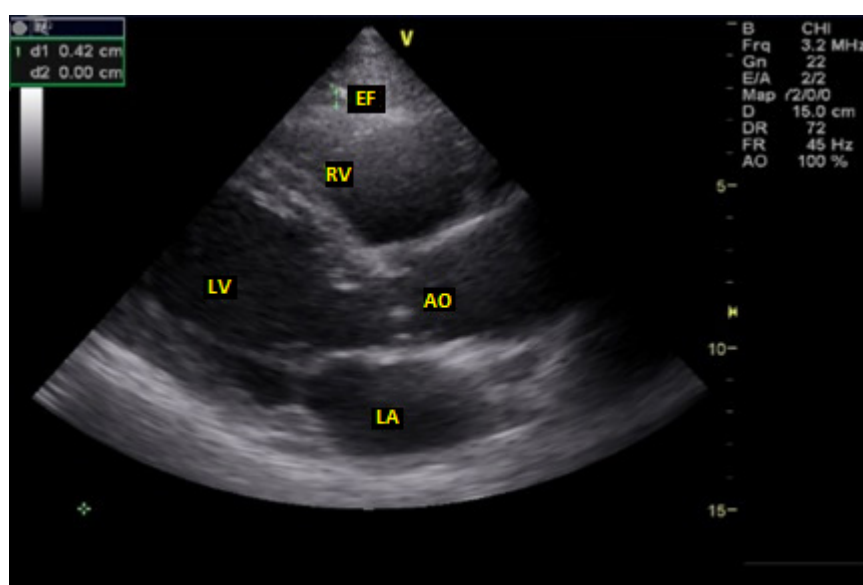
Measurement of epicardial fat by transthoracic echocardiography in the long-axis parasternal view.
